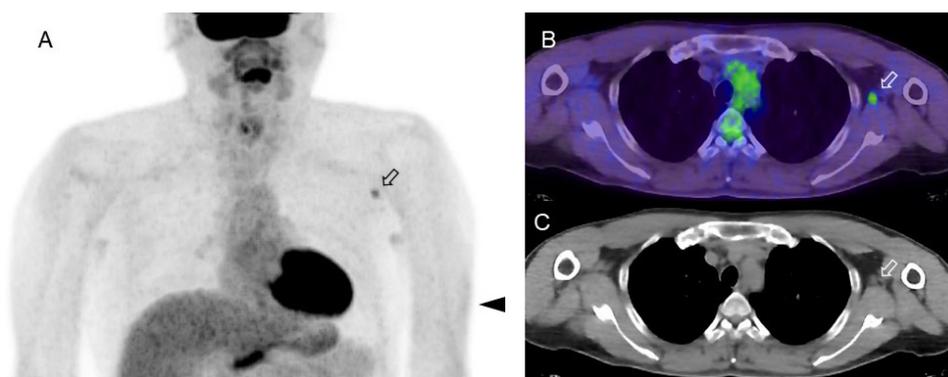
FDG-PET/CT images in a subject who received an influenza vaccination 4 days before the imaging examination. (A) MIP image, (B) axial fusion image, (C) CT image. Focal FDG uptake is seen in an axillary lymph node, which was slightly enlarged on CT image. Slight FDG uptake in the left arm indicates the site of COVID-19 vaccine injection at subcutaneous tissue (arrowhead). There are slight and symmetrical FDG uptake in the bilateral axillary area due to non-specific uptake for sweat glands.
